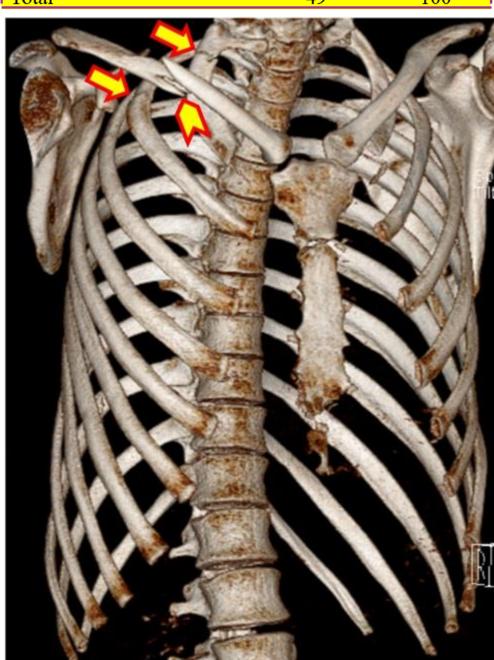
27-year-old male, fell from more than two-meter height. CT scan of the chest showed bilateral apical small pneumothorax, surgical emphysema, right 1st and 2nd ribs fracture (arrow), right clavicle fracture (arrowhead), and left 1st rib fracture.
